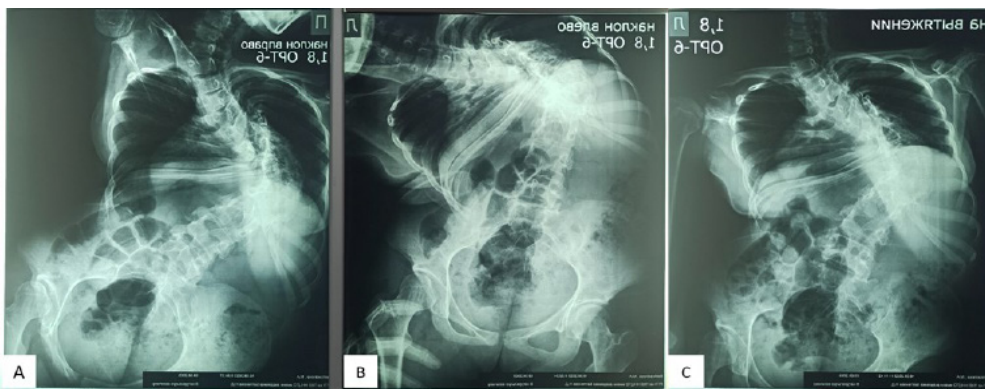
X-rays with functional samples A - inclination to the right, B - inclination to the left, C - on stretching
